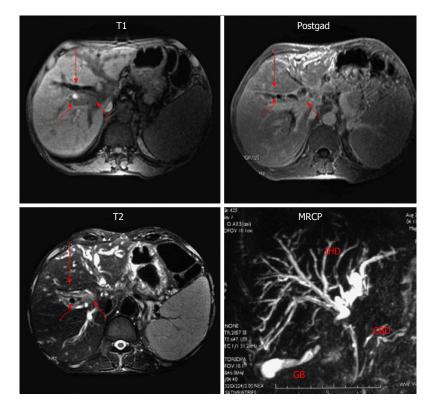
Magnetic resonance imaging with Magnetic retrograde cholangiogram in a patient with portal biliopathy. T1 weighted, T2 weighted and postgadolinium (postgad) images. Mass lesion (short arrow) is seen at the level of porta hepatis with dilated bile ducts (long arrow) and signal void (curved arrow), depicting collateral channels compressing bile ducts, MRCP. Common bile duct (CBD) shows luminal irregularity. There is a localized irregular stricture in common hepatic duct with upstream gross dilatation of intrahepatic ducts (IHD).
